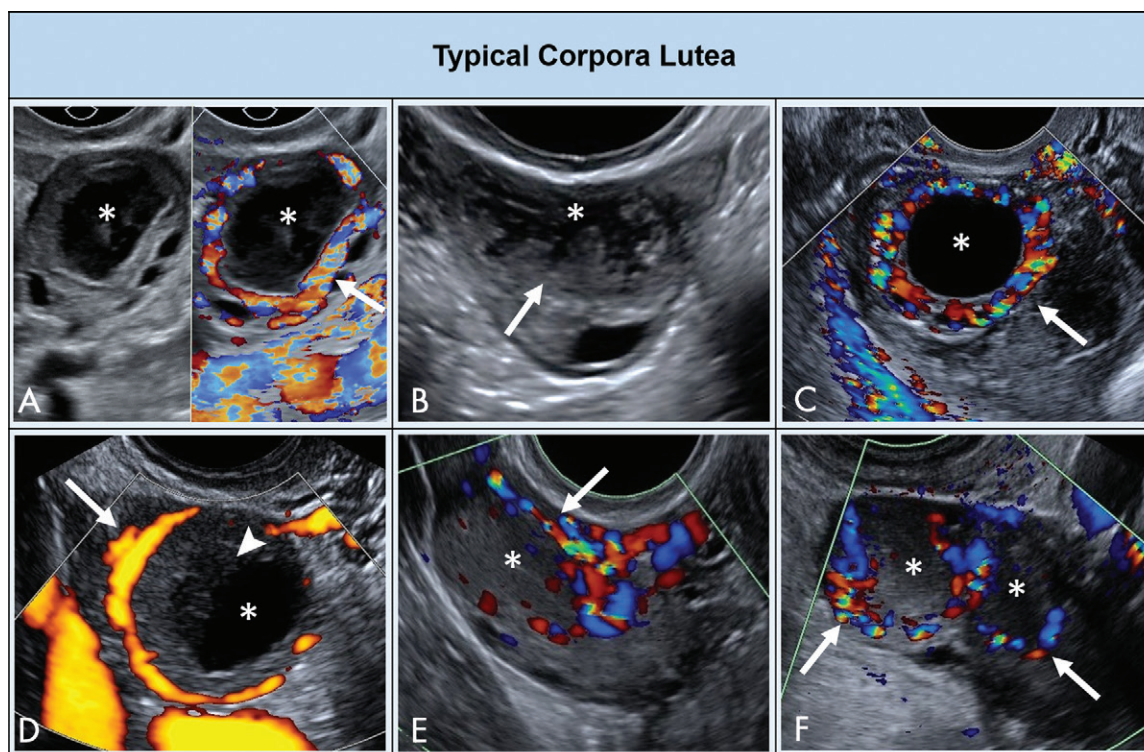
Images show typical corpora lutea. A, Corpus luteum with color Doppler and without color Doppler demonstrates central cystic component (asterisks) with smooth thickened wall, avascular internal echoes, and peripheral vascularity (arrow). B, Corpus lutea with central component, thickened wall, and crenulated inner margin (arrow). C, Anechoic thick-walled cyst (asterisk) with intense peripheral vascularity (arrow). D, Color Doppler energy demonstrates peripheral vascularity (arrow) in this cystic (asterisk) corpus luteum with retracting clot (arrowhead). E, Corpus luteum as hypoechoic region (asterisk) without central cystic component but with peripheral flow (arrow) at color Doppler. F, Two corpora lutea in setting of dual ovulation manifest by two hypoechoic regions (asterisks) with peripheral flow (arrows).
